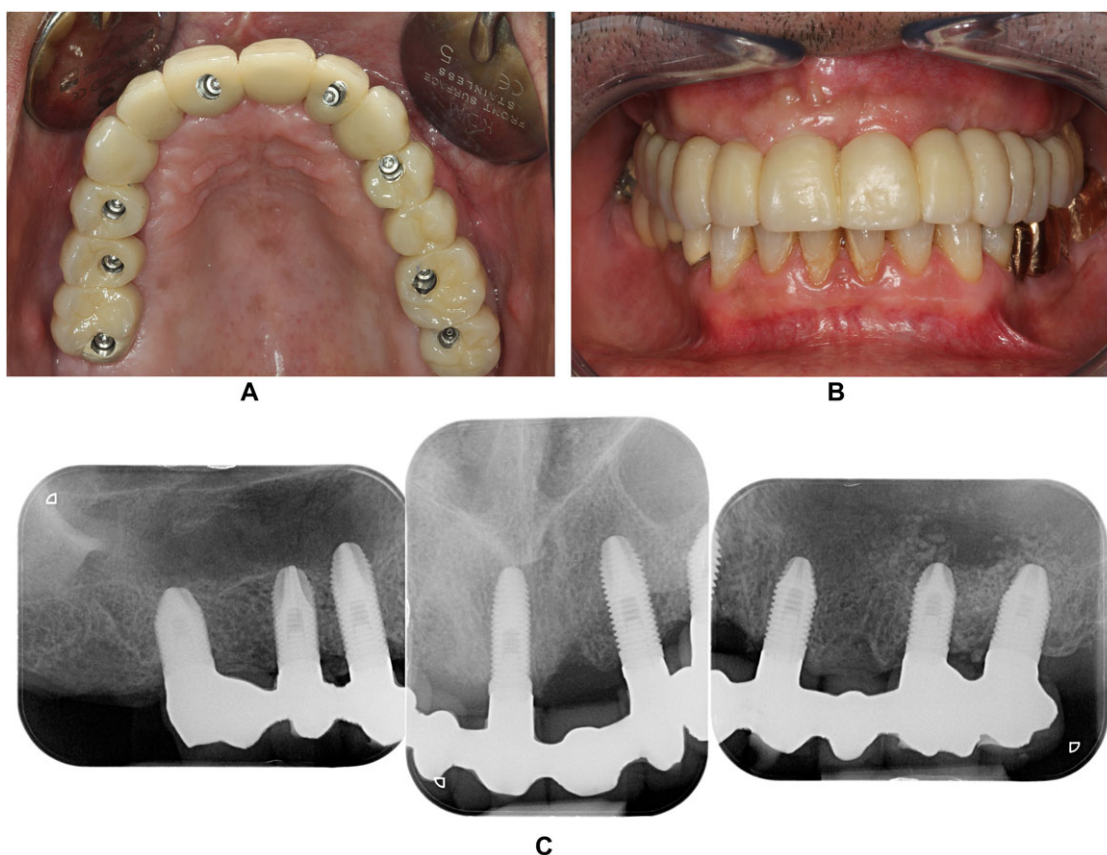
(A) Frontal view of the definitive maxillary fixed metal-ceramic prosthesis; (B) occlusal view of the definitive maxillary fixed metal-ceramic prosthesis; and (C) periapical radiographs of the completed definitive prosthesis.
